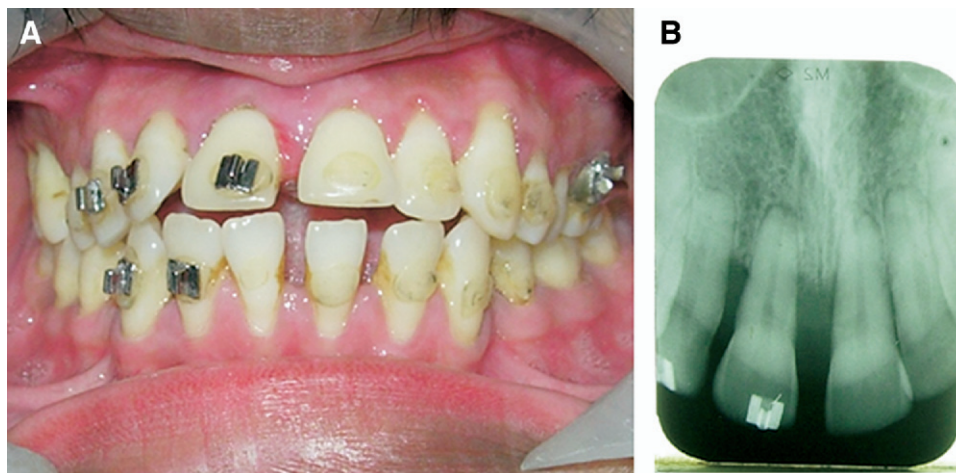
Image (A) shows the consequence of faulty mechanics by a general practitioner. Note improper bracket placement, improper removal of adhesive flash resulting in plaque harboring areas, and gingival recession in the mandibular anterior region. Note also the position of molar band, which is prone to induce attachment loss, gingival recession, and infrabony pocket formation. Image (B) is the radiograph of the maxillary anterior region from the same patient. Note the amount of bone loss and root shortening. (Picture courtesy of Arun Sadasivan, MDS, periodontist, Trivandrum, Kerala, India.) (Color version of figure is available online.)
